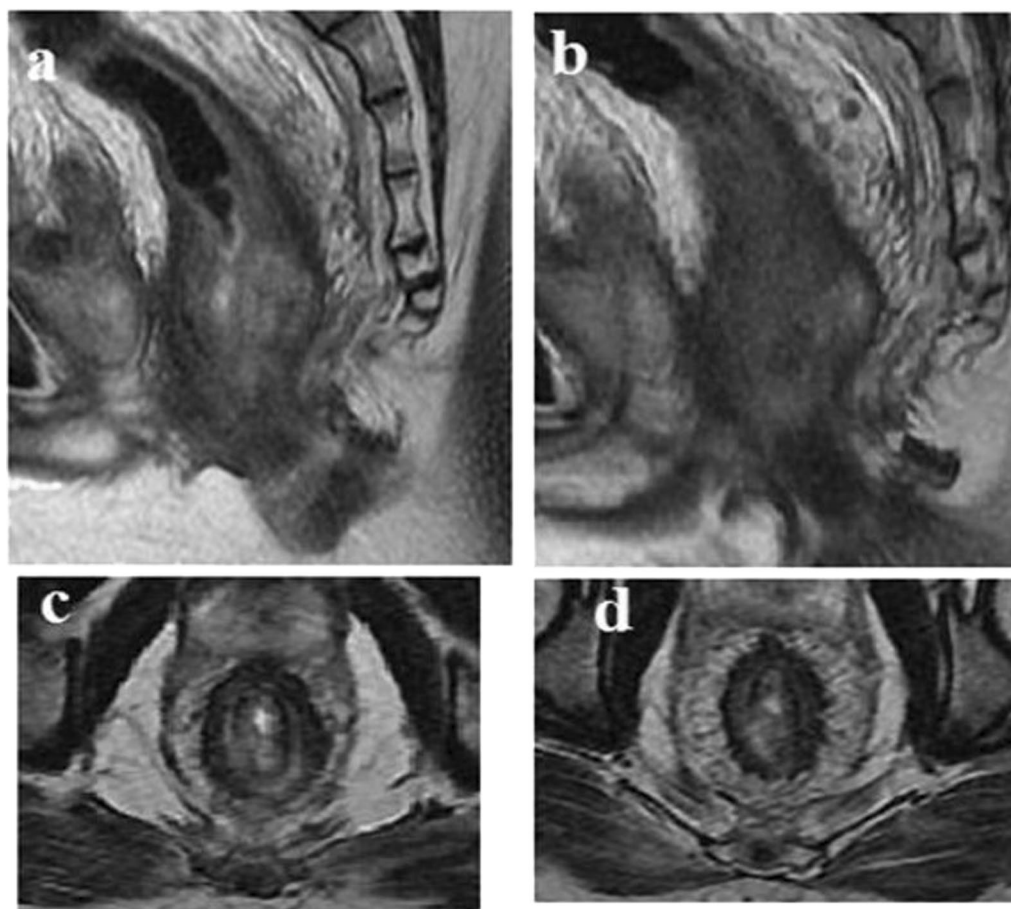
a–d Follow-up MRI study for same patient in Fig. 1. a, b sagittal T2 WIs, c, d axial T2 WIs, revealed better delineation of focal area of intermediate T2 signal seen involving the lower rectum (correlated to the same area found on the PET CT scan, 6–7 O'clock) and showing size progression as well, confirming the viable tumoral growth that was missed on the previous MRI due to the predominant fibrotic signal
